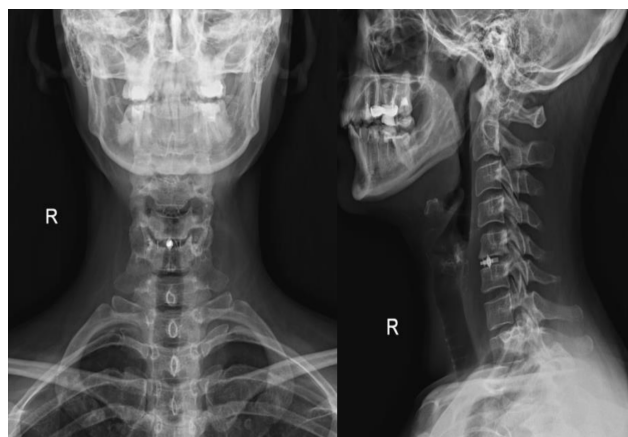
Postoperative antero-posterior and lateral plain X-ray at 12 months presenting the implant
